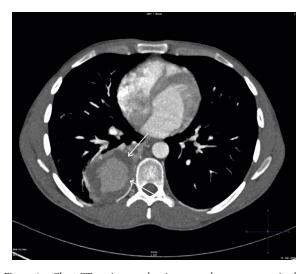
Chest CT angiogram showing a new large aneurysm in the right lower lobe with thrombus formation surrounding the aneurysm (arrows) giving rise to a heterogeneous appearance.
